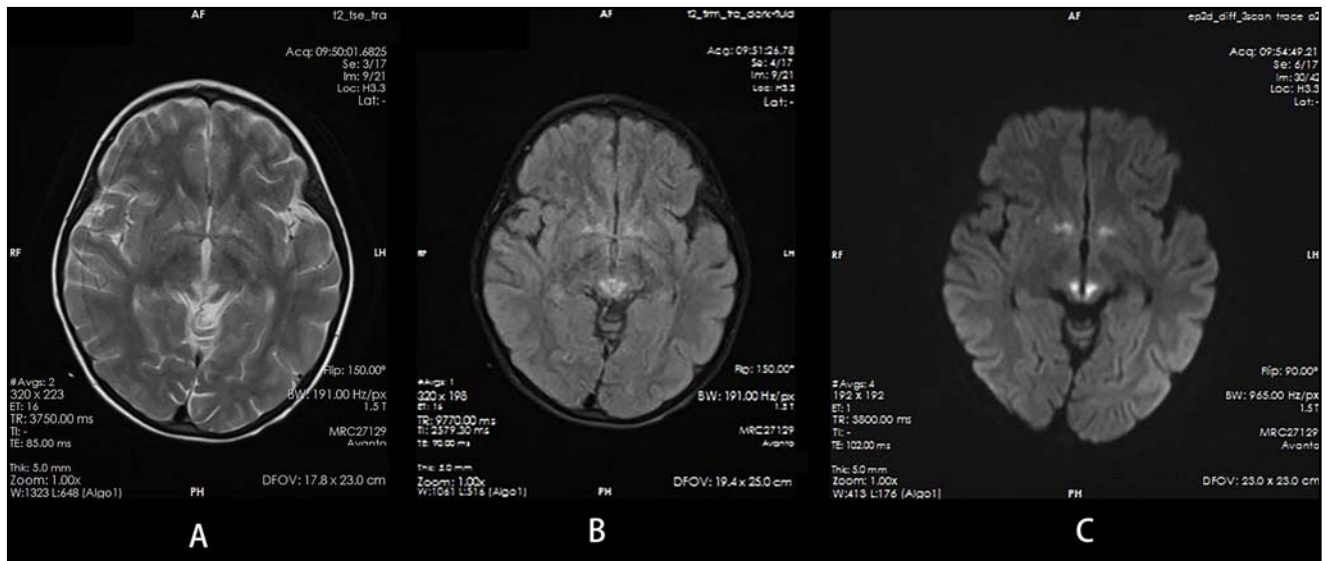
Non-contrast MRI scans of the head of the patient alongside diffusion-weighted imaging (DWI)—A: Prolonged T2 signal intensities within the bilateral basal ganglia and the interpeduncular fossa located between the cerebral peduncles. B: T2W-Flair sequence shows slightly elevated signal intensity. C: DWI shows slightly elevated signal intensity.
